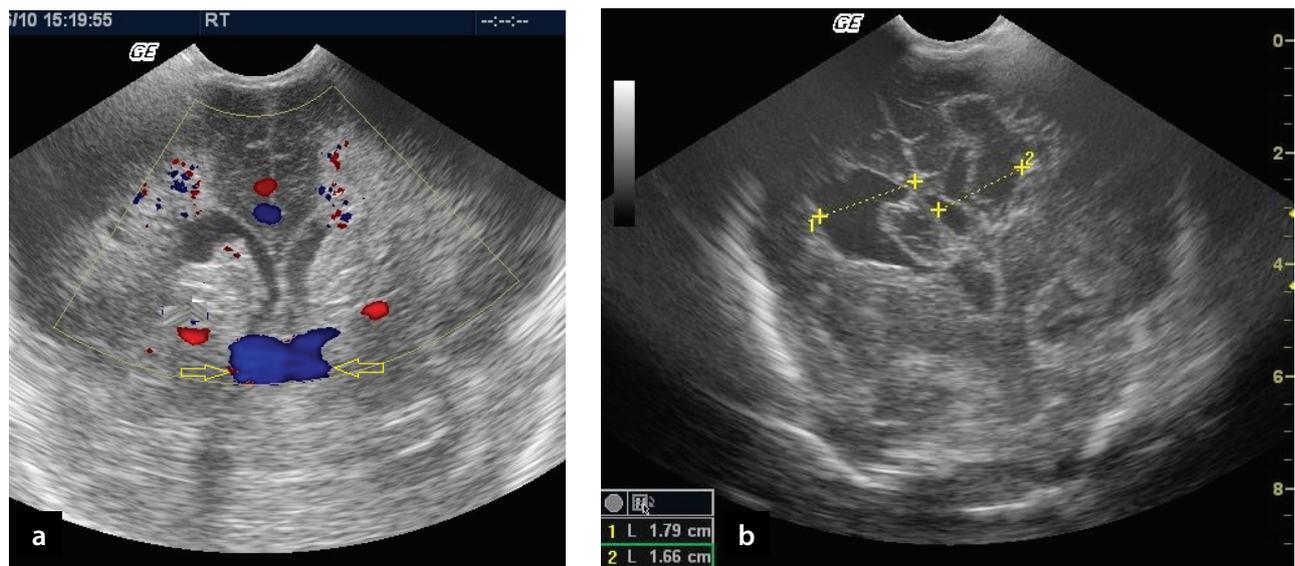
Neonate 29 GWs with bilateral PHI: a. Colour Doppler image-coronal section. No TV flow is detected bilaterally, whereas internal cerebral veins are apparent (arrows). b. Ten days later. Hypochoic thrombi remain within the dilated lateral ventricles and porencephalic cysts have already developed.
